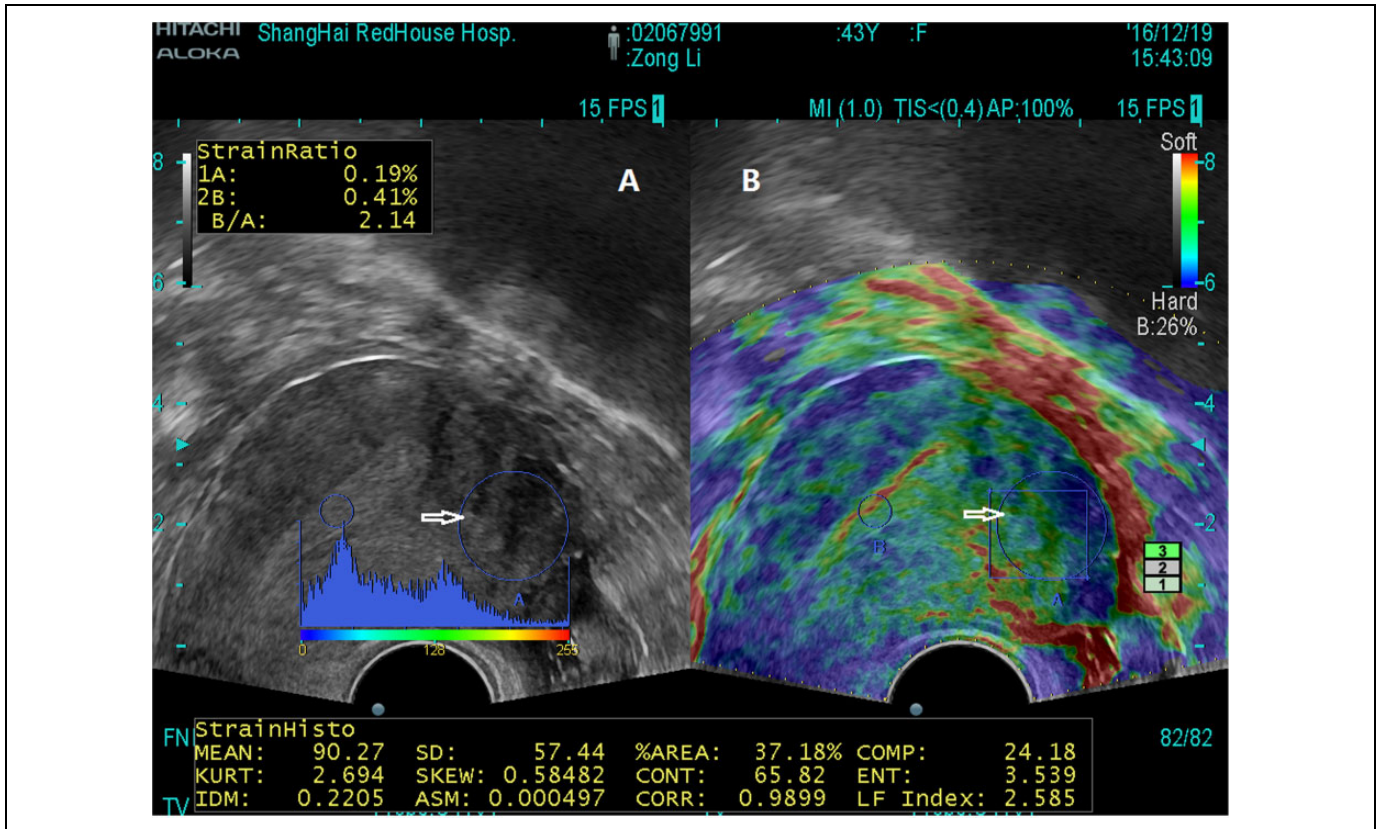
A. Transvaginal ultrasound image for a patient with a small uterus ($59 \times 58 \times 57$ mm) who complained of moderate dysmenorrhea with elevated CA125 level and was suspected with AM. The big circled area (white arrows) showed the ROI. The conventional B-mode TVUS image showed no sign that was consistent with a typical or spherical enlarged uterus or the presence of mild but not severe or obvious internal inhomogeneous echo in ROI. B. Transvaginal elastosonography image showing an increased stiffness value (LFI = 2.585) in the same ROI shown in the TVUS (white arrow), indicative of adenomyosis. AM indicates adenomyosis; LFI, liver function index; ROI, region of interest; TVUS, transvaginal ultrasound.
